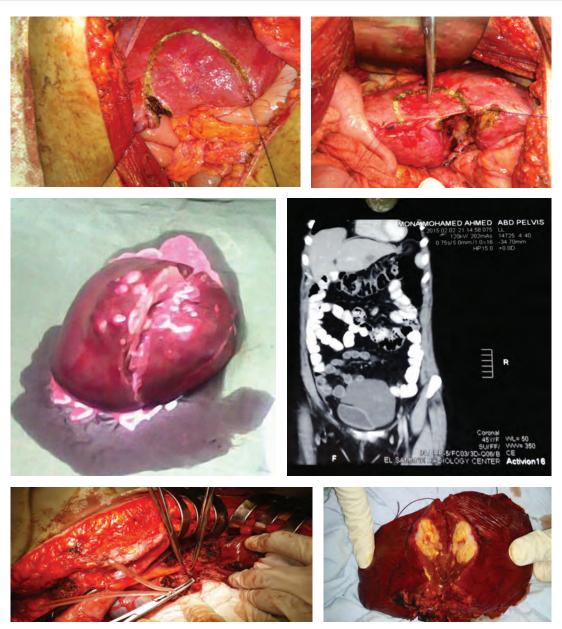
Bilobar liver metastases resection, right hepatectomy & left liver metastases. A. Demarcation of left liver metastases excision. B. Demarcation of right liver metastases excision. C. Right lobe hepatectomy. D. CT Abdomen showed left liver metastases. E. Left lateral segment hilum dissection. F. Opening of the liver metastases.
